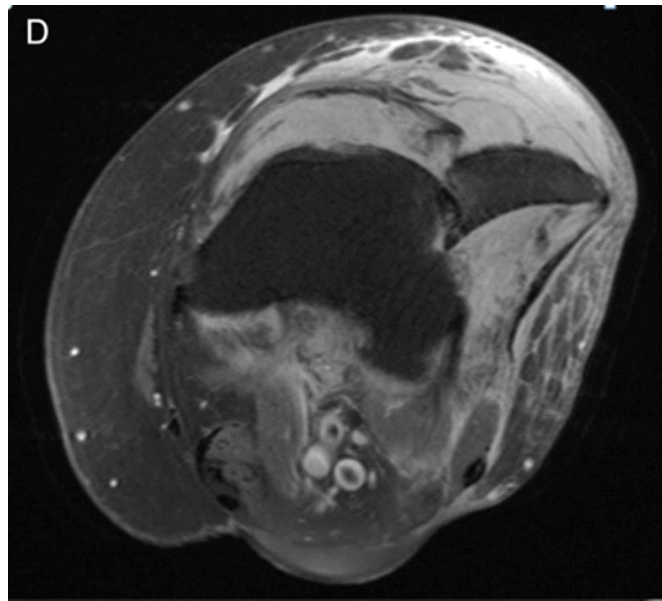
Axial cut of magnetic resonance imaging of the left knee with lateral patella dislocation with the medial border of the patella impacted on the lateral femoral condyle. Osteophytes also noted between the patella and femoral condyle.
